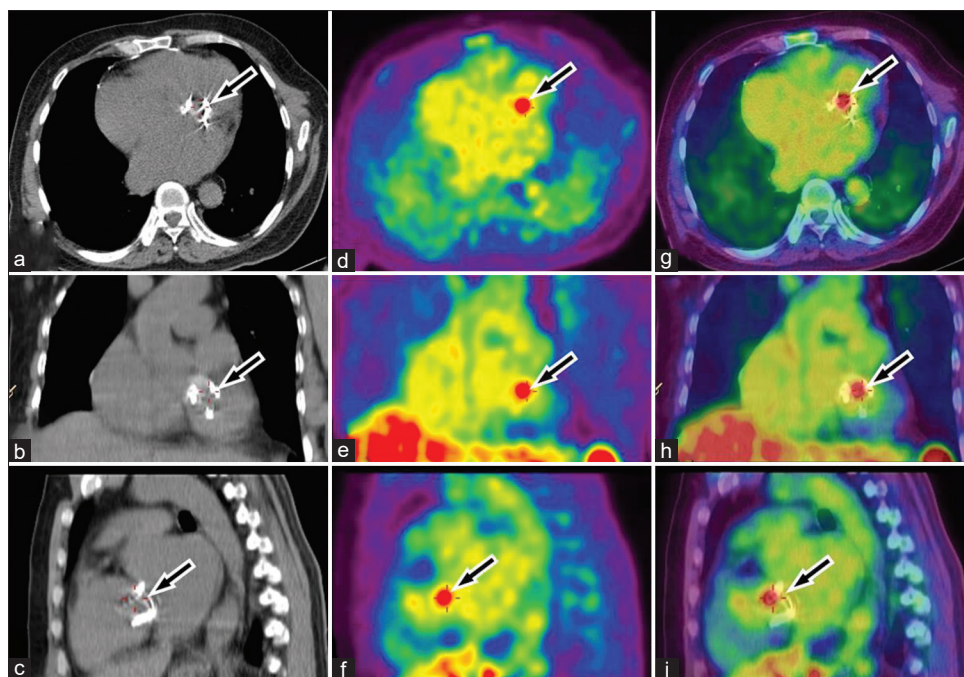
Transaxial (a), coronal (b) and sagittal (c) noncontrast computed tomography images show the mitral prosthetic valve (arrow). On transaxial (d), coronal (e) and sagittal (f) positron emission tomography, and transaxial (g), coronal (h), and sagittal (i) fused positron emission tomography-computed tomography images, focal increased ^{18}F -fluorodeoxyglucose uptake is seen in the prosthetic valve (arrow, SUV_{max} 5.3), suggestive of prosthetic valve endocarditis. Post removal culture from the prosthetic valve showed growth of *Candida albicans*
